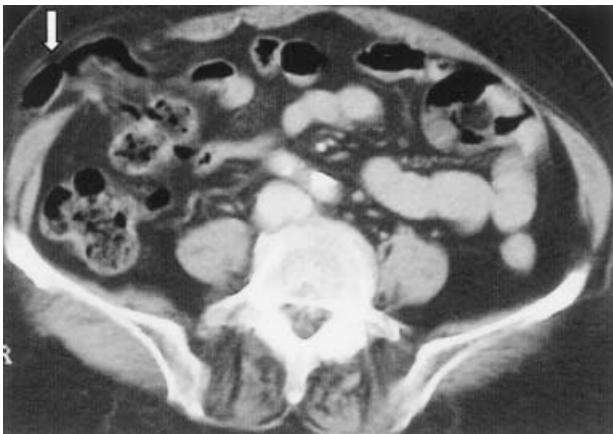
Findings of abdominal CT. The symbol shows air density, which suggests herniated intestine into the subcutaneous layer.
